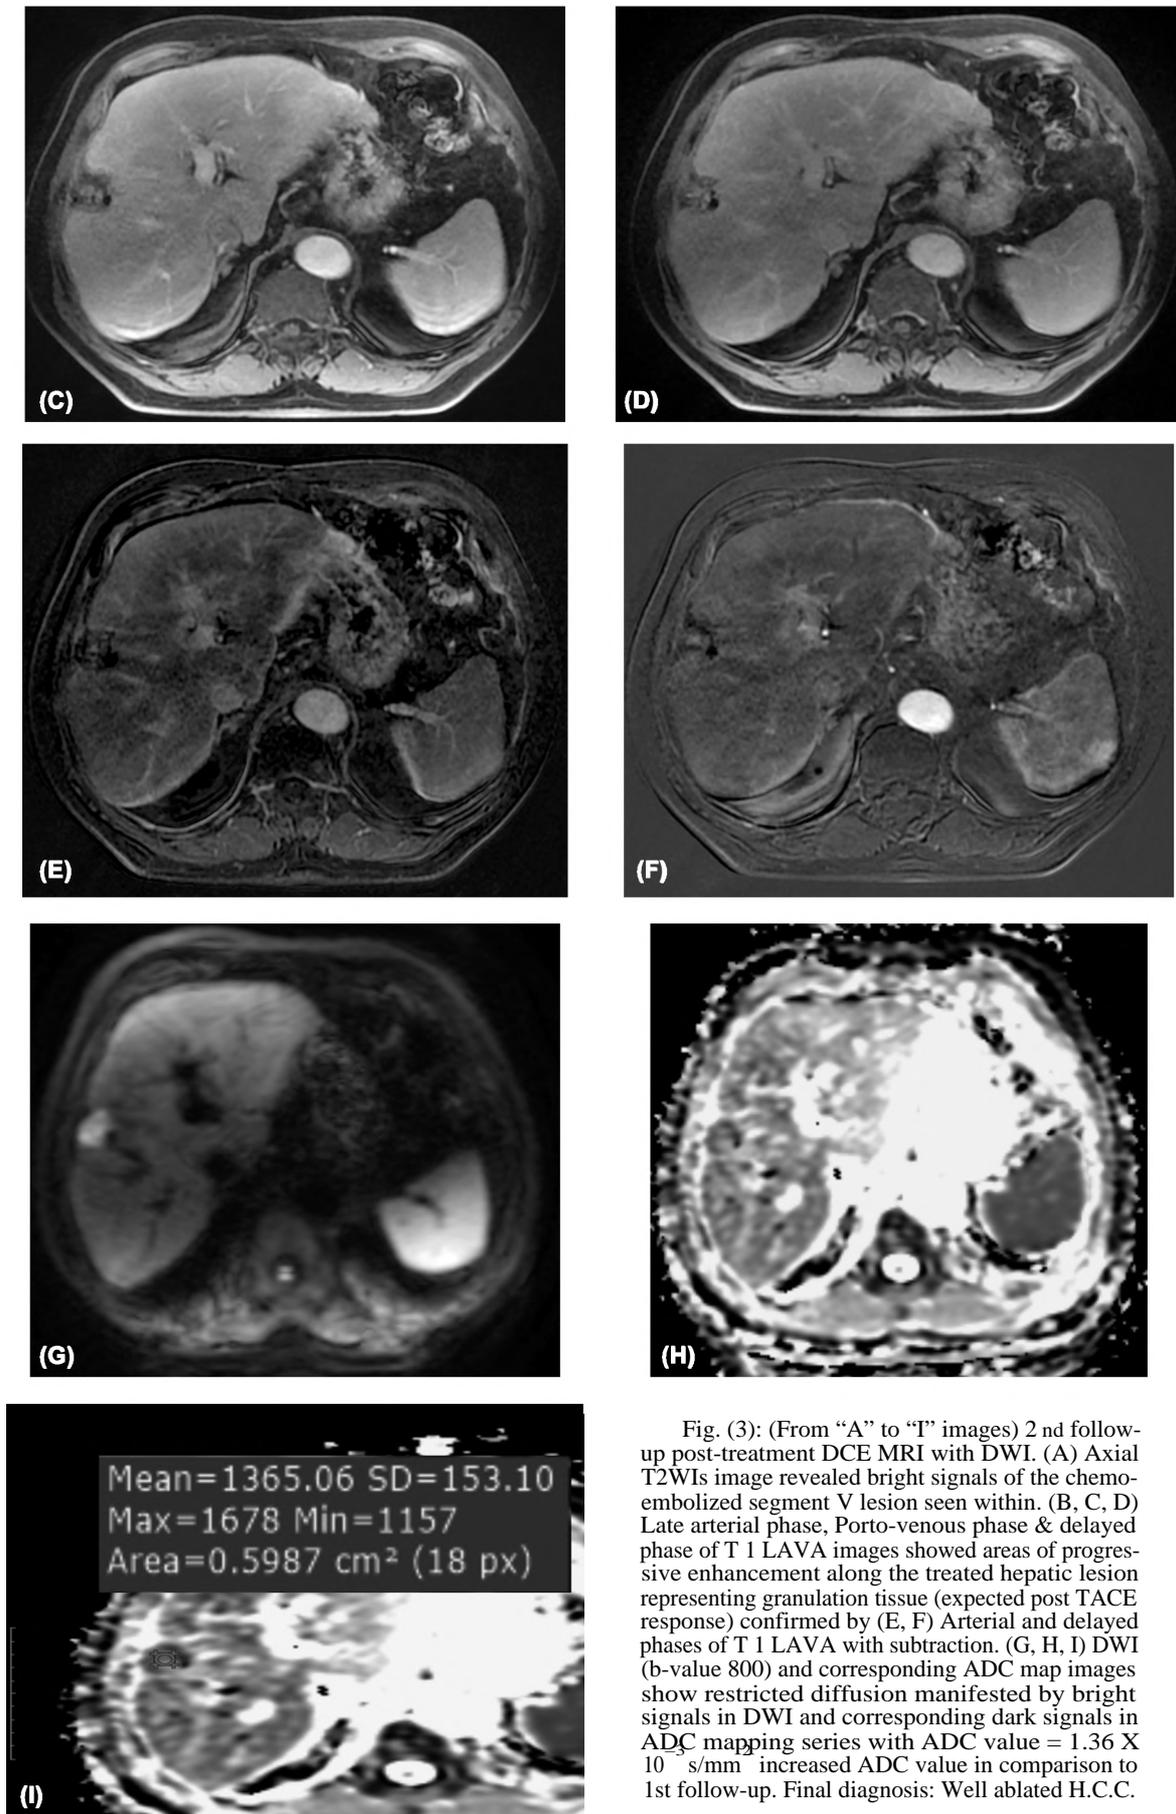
(From “A” to “T” images) 2<sup>nd</sup> follow-up post-treatment DCE MRI with DWI. (A) Axial T2WIs image revealed bright signals of the chemo-embolized segment V lesion seen within. (B, C, D) Late arterial phase, Porto-venous phase & delayed phase of T1 LAVA images showed areas of progressive enhancement along the treated hepatic lesion representing granulation tissue (expected post TACE response) confirmed by (E, F) Arterial and delayed phases of T1 LAVA with subtraction. (G, H, I) DWI (b-value 800) and corresponding ADC map images show restricted diffusion manifested by bright signals in DWI and corresponding dark signals in ADC mapping series with ADC value =  $1.36 \times 10^{-3} \text{ s/mm}^2$  increased ADC value in comparison to 1<sup>st</sup> follow-up. Final diagnosis: Well ablated H.C.C.
